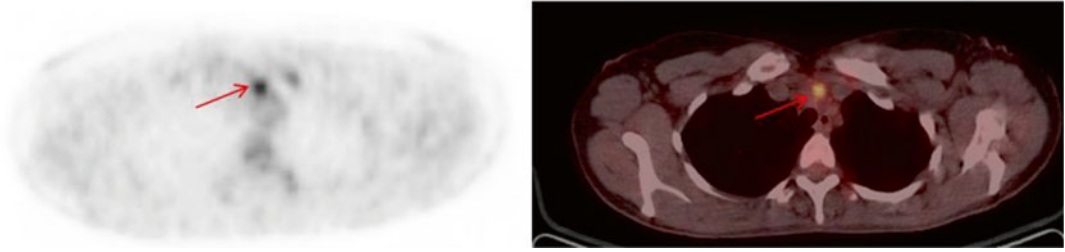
PET/CT after the end of ABVD therapy. Hypermetabolism at the anterior mediastinum
